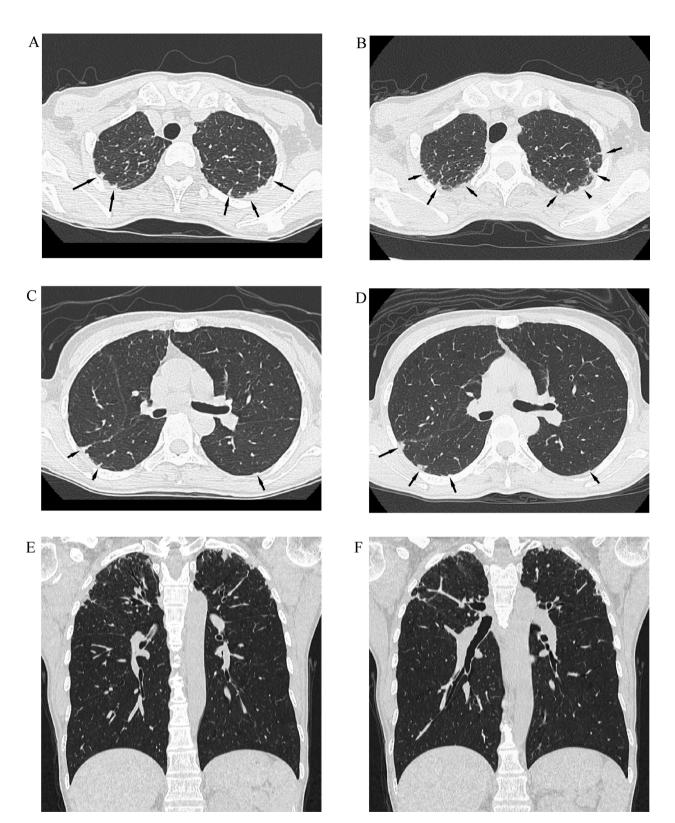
40-year-old woman with pleuroparenchymal fibroelastosis (PPFE)-like finding on CTs which were initially taken for an investigation of chronic cough. Initial CT images at the apical and hilar levels show bilateral and subpleural dense consolidation with mild distortion consistent with PPFE (2A, C. arrows). Threeyears later, mild increasing of the PPFE-like lesions (2B, D), and the upward shift of the interlobar fissure can be seen (arrowheads).
